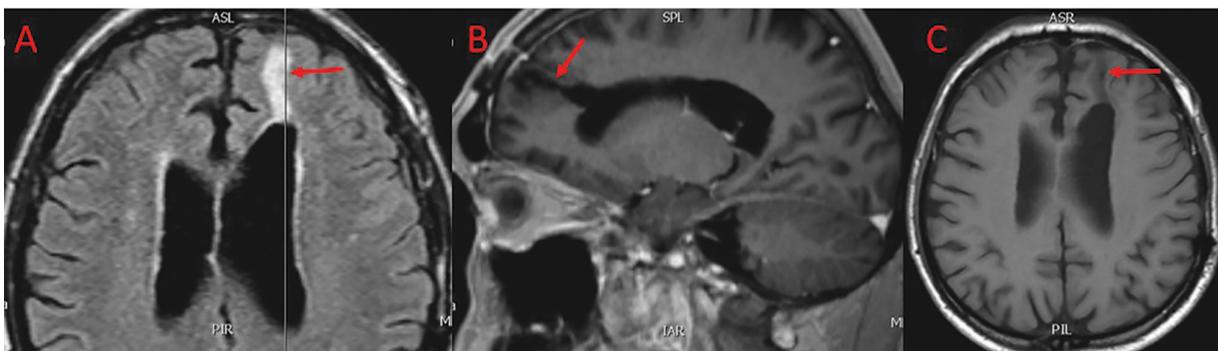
Control MRI three months after the operation. The tumour has been removed completely and the trace of the endoport can still be seen (arrow), morphologically confirming that very little brain trauma has been inflicted with such approach. The subdural haematoma has been resorbed completely (A, B). Follow-up MRI three years after the surgery shows a barely visible trace of the endoport access (arrow) (C).
